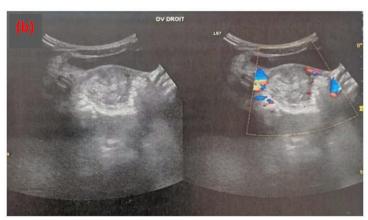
Abdominopelvic ultrasound (a) and Doppler ultrasound appearance (b) showing a heterogeneous ovarian mass
